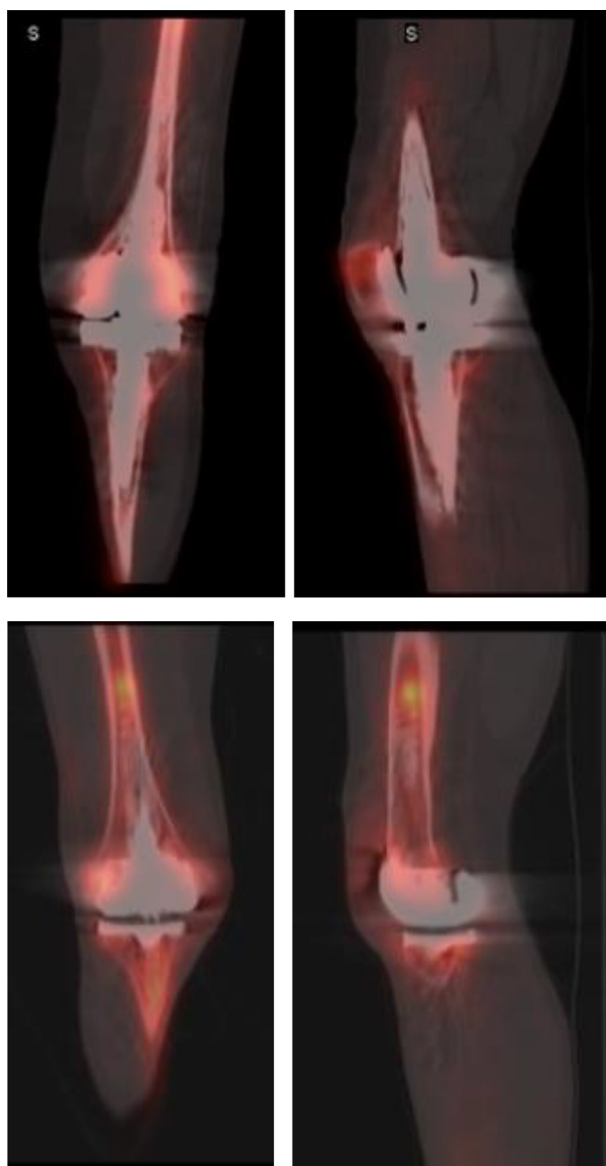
Example SPECT-CT images of cases considered by our radiologists are being negative, equivocal, and positive for prosthetic loosening.
